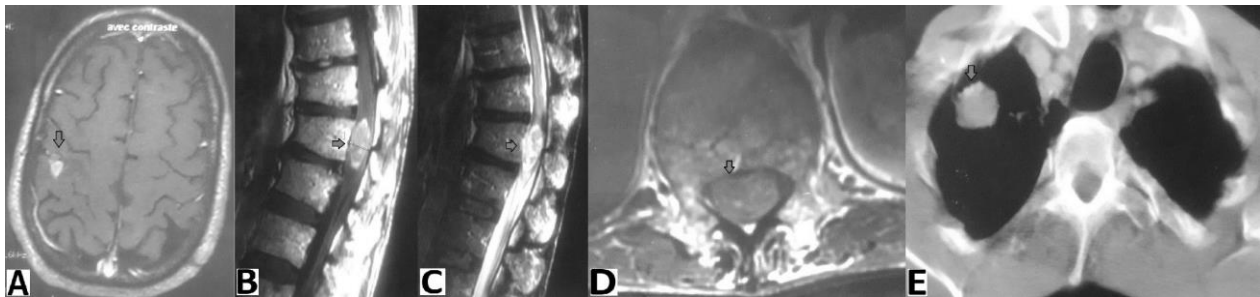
Images of patient 1; (arrows: the tumour in different locations). (A): axial T1 injected brain MRI, objectifying the right parietal metastasis; (B): sagittal T1 WI injected spinal MRI showing the enhancement of conus medullaris nodule; (C): sagittal T2 WI spinal MRI; (D): axial T1 WI spinal MRI; (E): axial thoracic CT, objectifying right apical pulmonary neoplasia with parietal extension.
